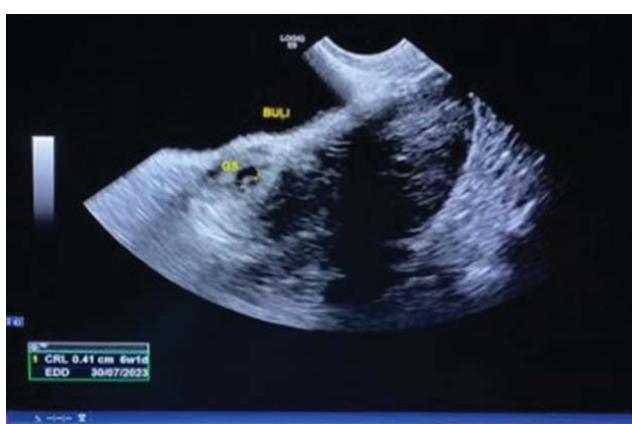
Transvaginal ultrasound revealed a left-sided mass suspicious of an extrauterine gestational sac with biometry similar to 6 weeks, no sign of free abdominal fluid, and no fetal heart rate.
